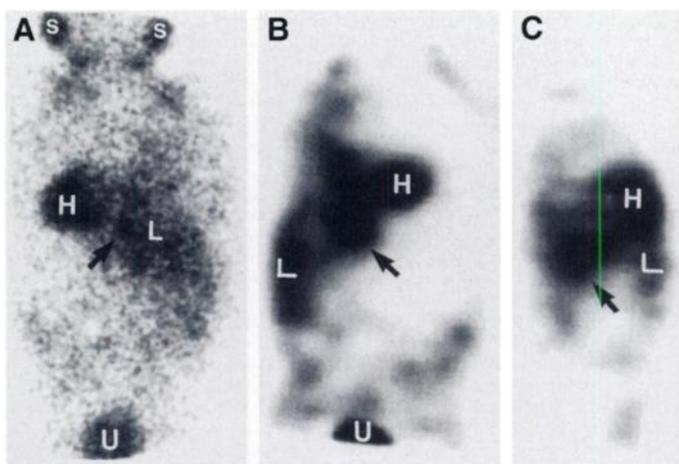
Same patient shown in Figure 2. (A) 48-hr posterior planar image, (B) posterior coronal 24-hr SPECT and (C) sagittal 24-hr SPECT clearly depict right lower paraspinal lesion in three dimensions (arrows). s = salivary glands, H = heart, L = liver, U = bladder.
